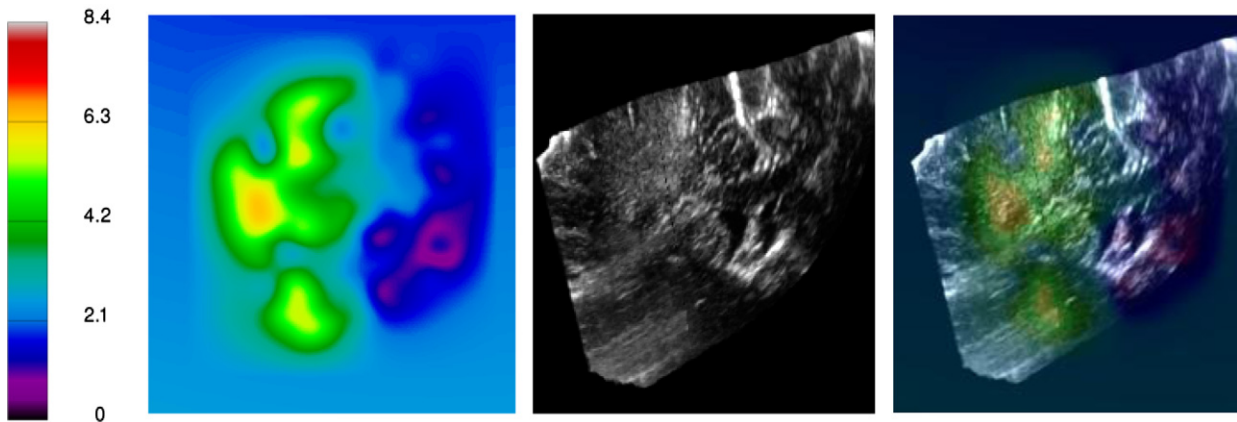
2D color map showing the magnitude of brain shift (in mm) as computed after rigid and nonlinear registrations of the pre- and postresection ultrasound images for patient #4 (left). The value outside the ultrasound image region is not 0 because of the rigid registration. Preresection ultrasound (center). The 2 previous images combined (right).
